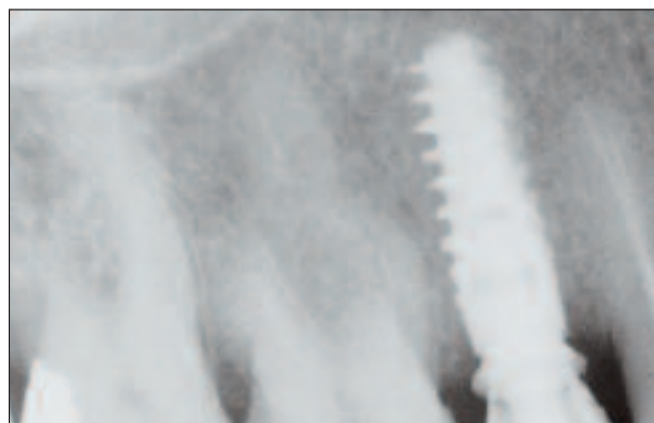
(below): Post operative radiograph UR5
